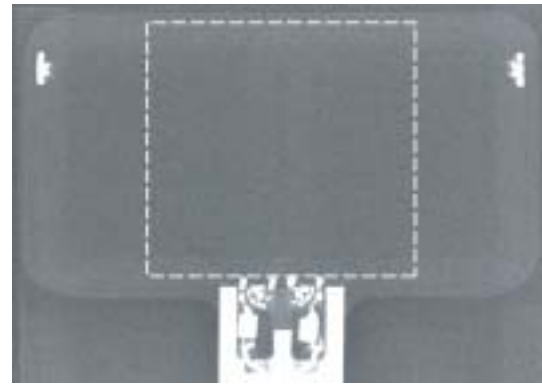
X-ray image of the x-ray compatible phased array coil. The approximate size and position of the x-ray detector is indicated by the white square.
